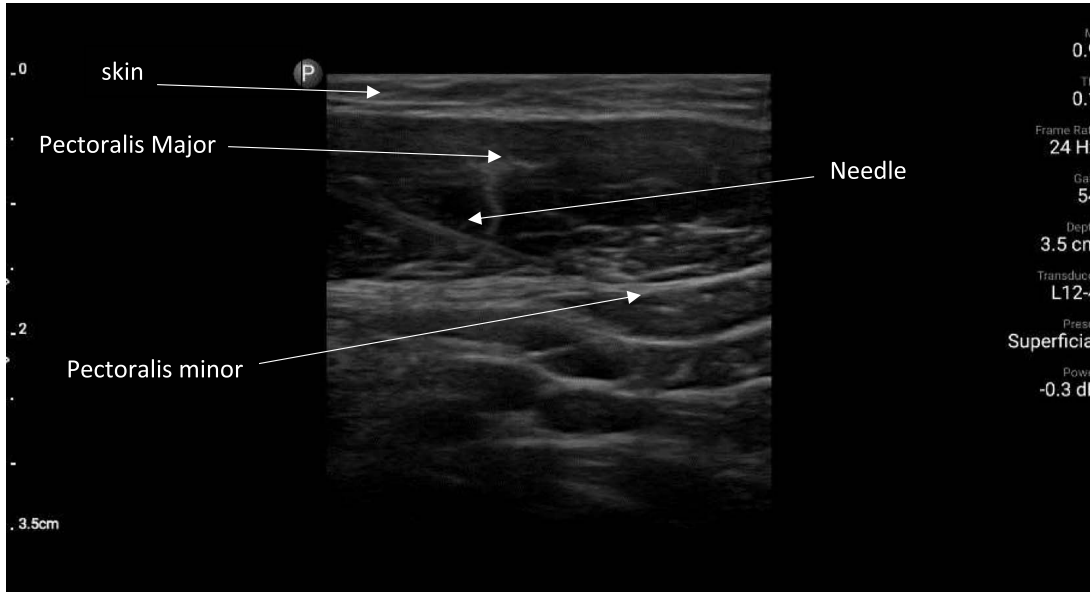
PEC-1 block: Ultrasound image showing the needle inserted between pectoralis major and minor muscles.
